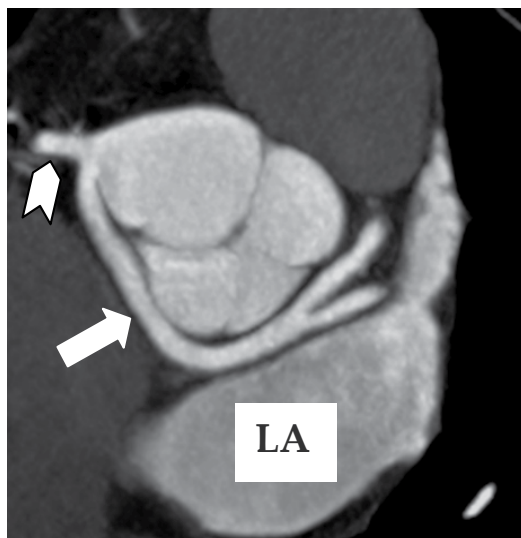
Computed tomography imaging of anomalous connection of the left main coronary artery (arrow) with the right sinus close to the right coronary artery (arrowhead). LA : left atrium.
